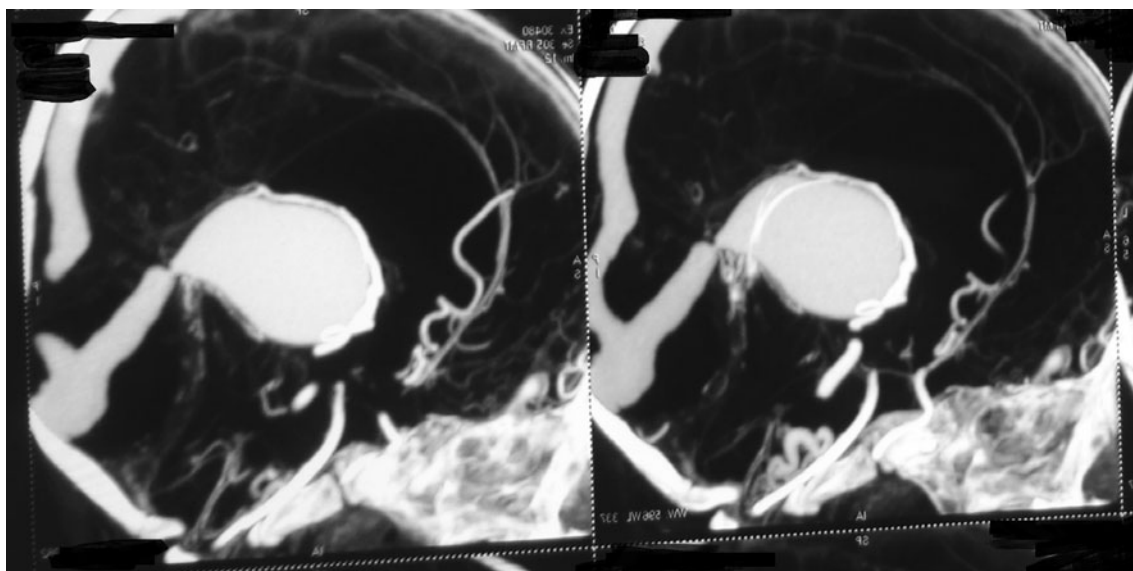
CT angiography shows Galen aneurysm with severely dilated torcula, straight sinus, which the straight sinus contains a short narrowing segment distal to the Galen
